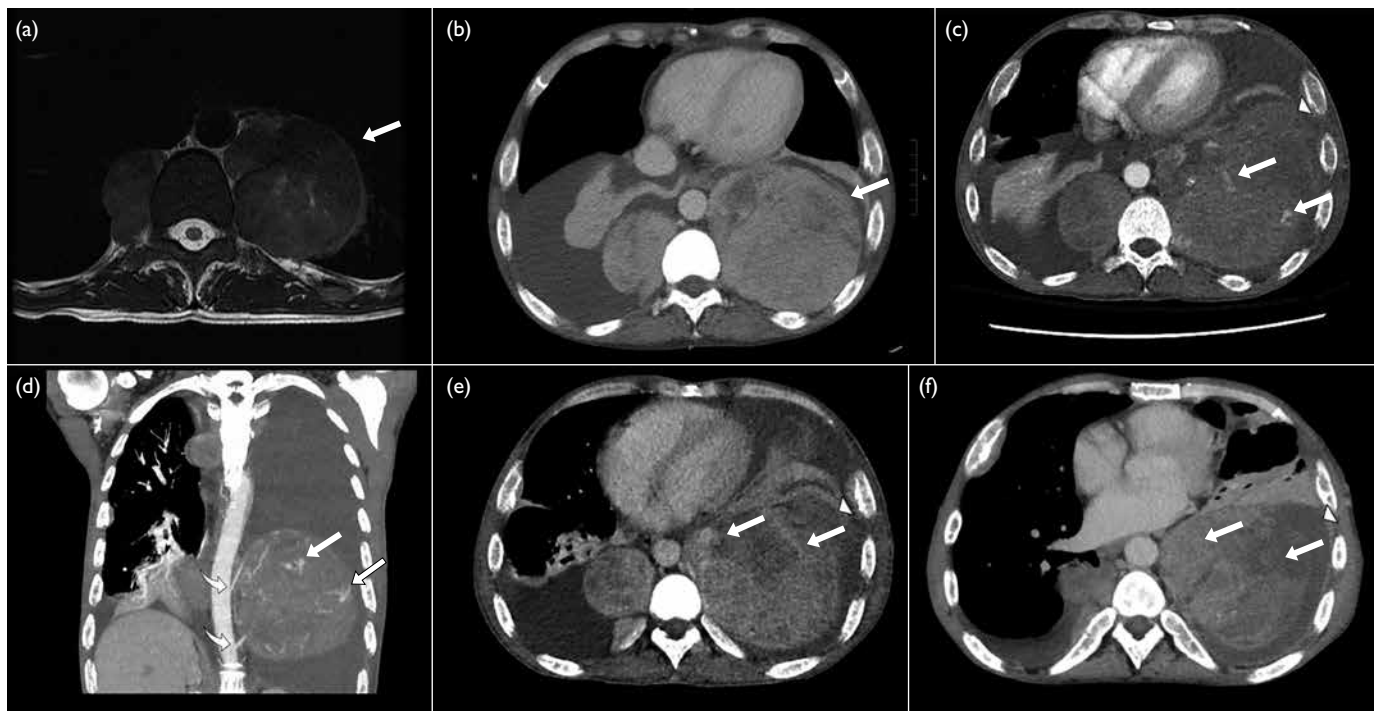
(a) Previous magnetic resonance imaging (MRI) of the thoracic spine of the patient in 2015. T2-weighted axial image showing multiple extramedullary haematopoiesis (EMH) in the bilateral paraspinal regions up to 8.3 cm on the left side (arrow). (b) Initial contrast-enhanced computed tomography (CECT) image in the axial portovenous phase showing bilateral pleural effusion and multiple EMH in the bilateral paraspinal regions, with the largest lesion in the left lower hemithorax up to 11.8 cm (arrow). Subsequent urgent CECT images 4 days later in (c) axial arterial phase, (d) coronal arterial phase with maximum intensity projection (MIP), and (e) axial portovenous phase showing a left haemothorax (arrowhead in [e]) and newly developed intralesional pseudoaneurysms and multiple dysplastic vessels (arrows) within the largest paraspinal EMH in the left lower hemithorax, indicating active bleeding. The MIP image enabled identification of the origin of the left intercostal arteries for preoperative planning (curved arrows in [d]). (f) Post-embolisation follow-up CECT image at 2 weeks in axial portovenous phase showed decreased vascularity of the left lower thoracic EMH (arrows) and low-density effusion, and reduction in haemothorax (arrowhead)
